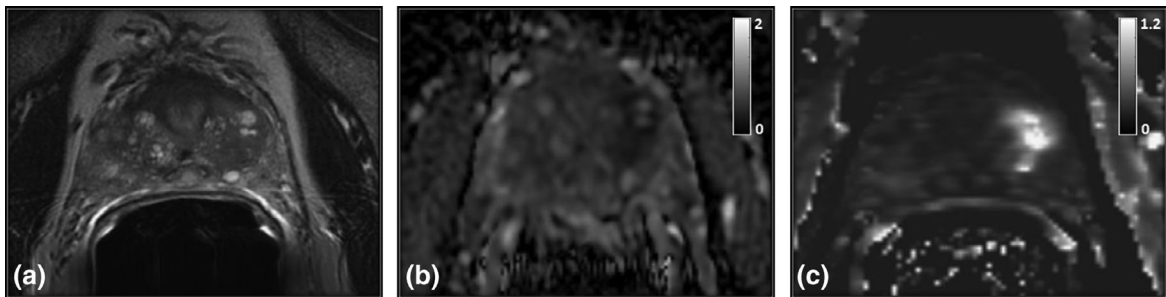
Representative pretreatment MR images of a patient with prostate cancer—Gleason Score 4 + 3 (66 years, male). (a) T_2 -weighted image, (b) $ADC \times 10^{-3}$ (mm^2/s) map generated using two b -values (ie, $b = 0, 600 \text{ s}/\text{mm}^2$), and (c) K^{trans} (min^{-1}) map generated from DCE data. (Images contributed by Susan M. Noworolski, University of California San Francisco.)
